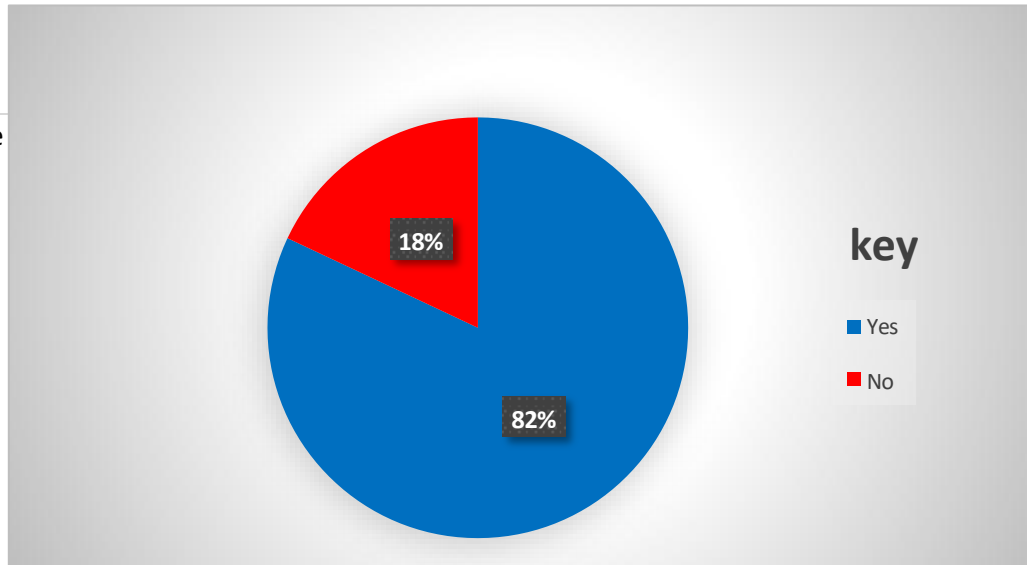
shows majority 82% said the ultrasound scan revealed fetal anomalies, whereas the minority 18% ultrasound scan revealed no fetal anomalies.
